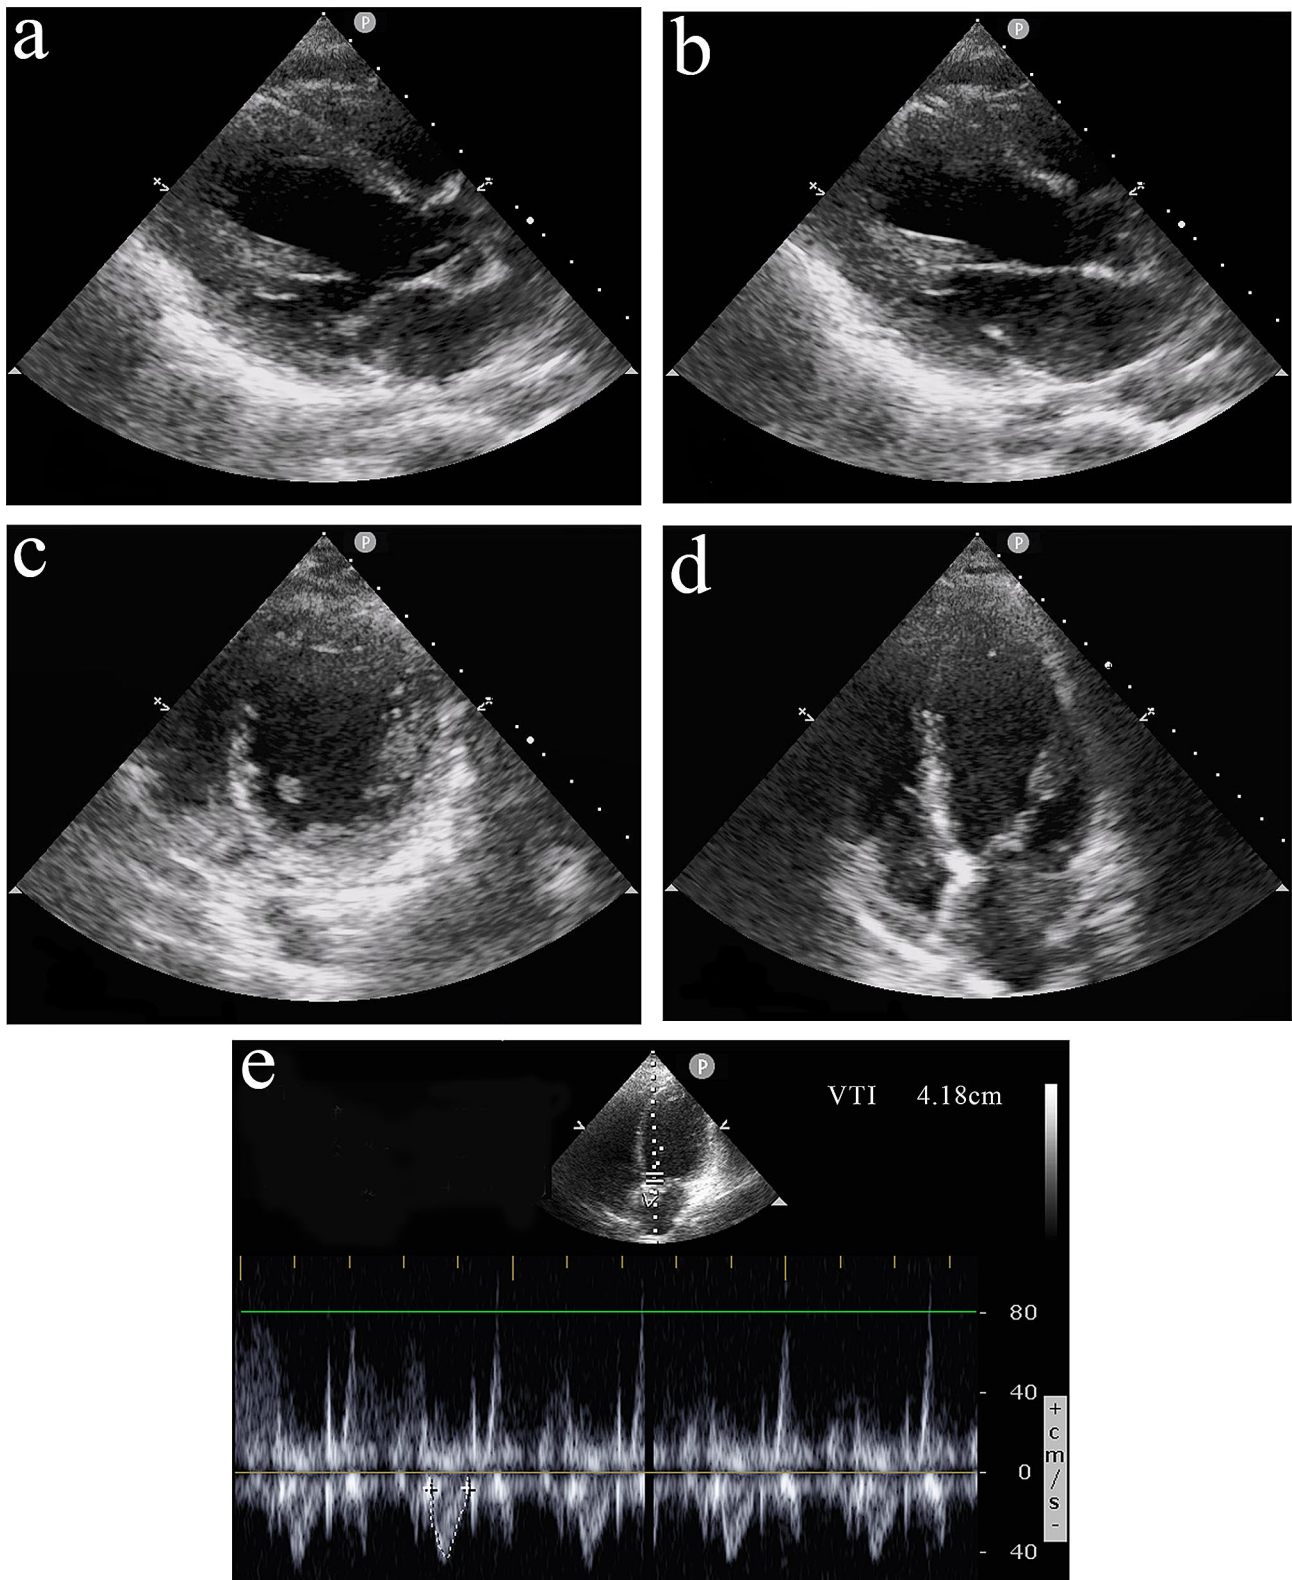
Transthoracic echocardiography on ICU Day 1. TTE presented severe cardiac dysfunction, left ventricular ejection fraction (17%), left ventricular outflow tract velocity time integral (LVOT VTI 4.18 cm), left ventricular end-diastolic (LVEDd, 50 mm), left ventricular end-systolic diameter (LVEDs, 43 mm) and interventricular septum thickness (7 mm). No regional wall motion was observed. (a) Parasternal long-axis views in systolic phase (b) Parasternal long-axis views in diastolic phase. (c) Parasternal short-axis view. (d) Apical four-chamber view. (e) Apical five-chamber view. Abbreviations: LVOT VTI, left ventricular outflow tract velocity time integral; LVEDd, left ventricular end-diastolic; LVEDs, left ventricular end-systolic diameter.
